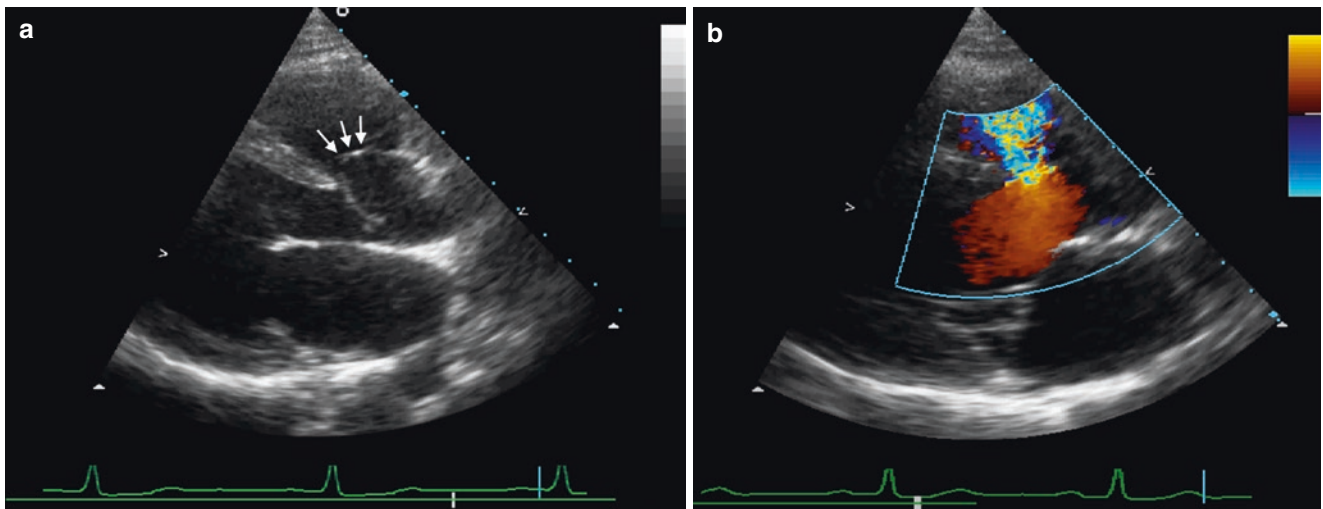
Parasternal long-axis view showing prolapse of the right coronary cusp of the aortic valve (arrows) in a patient with a small doubly committed VSD (a). Colour Doppler reveals LR-shunting across the defect underneath the aortic valve (b)
